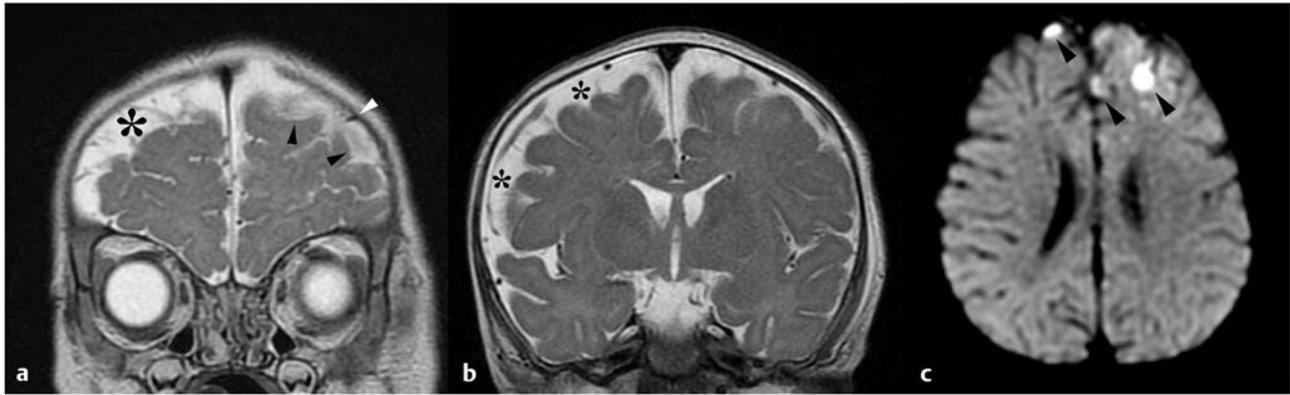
(a) A 6-month-old infant developed pneumococcal meningitis. Coronal T2-weighted magnetic resonance imaging shows prominence of the subarachnoid spaces (black asterisks). Over the left frontal convexity is an extracerebral collection with intensity slightly lower than that of cerebrospinal fluid (black arrowheads). This collection is confirmed to be in the subarachnoid space by the presence of a vascular flow void (white arrowhead) within it. (b) Diffusion-weighted imaging sequence from the same study shows droplets of high-signal pus lying in a sulcus and (c) on the surface of several gyri (black arrowheads).
